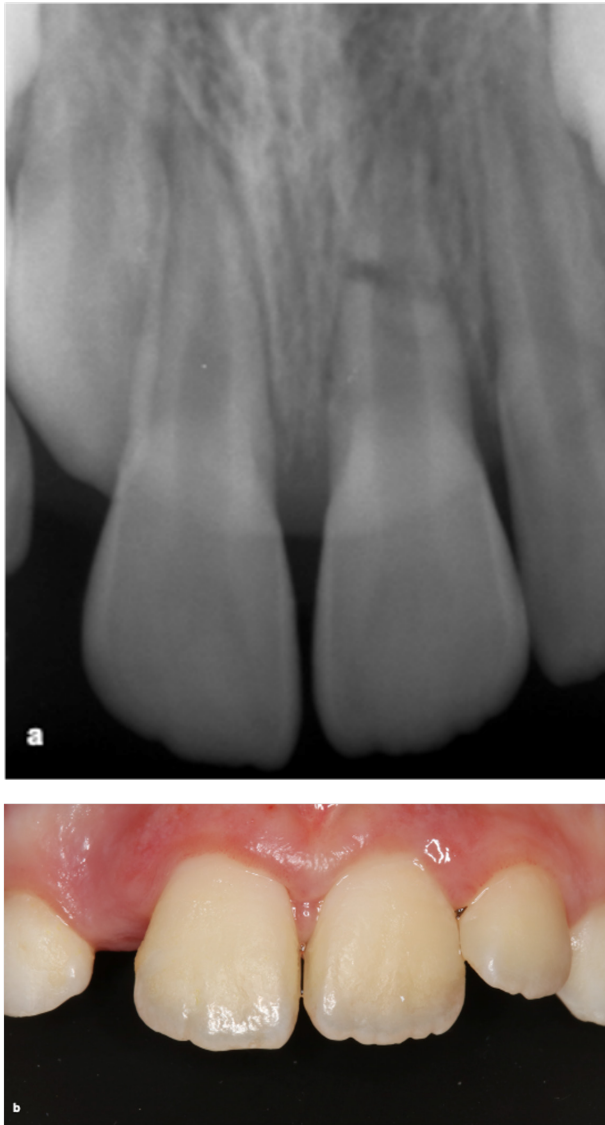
a) Initial intraoral periapical radiograph b) Initial intraoral view
